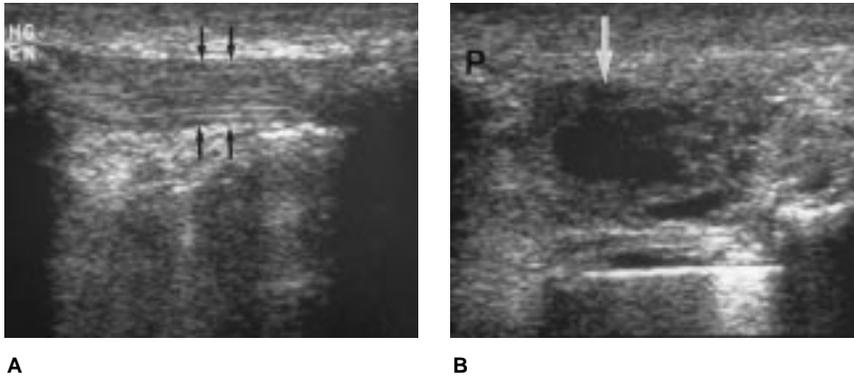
A, Sagittal ultrasound image of a normal patellar tendon (arrows). Note the shadowing effect of the patella and tibia. B, Acute patellar tendon rupture (arrow). Note the confluent region of hypoechoogenicity extending completely through the tendon at the site of rupture. P = patella.
